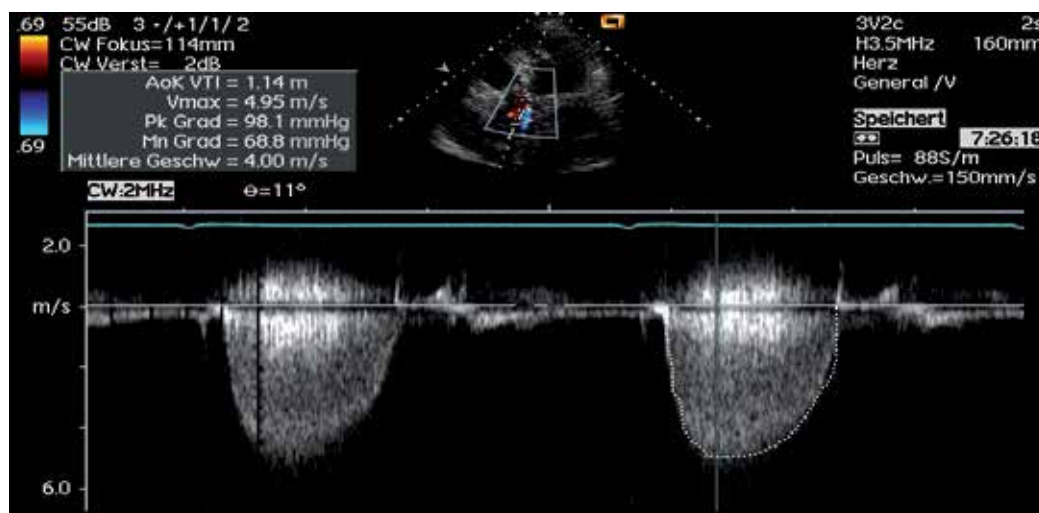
Using an apical five-chamber view, transvalvular continuous Doppler shows a severe to very severe aortic stenosis, with mean/peak systolic gradients of 69 and 98 mmHg, respectively, and a peak systolic velocity of 4.9 m/s.
